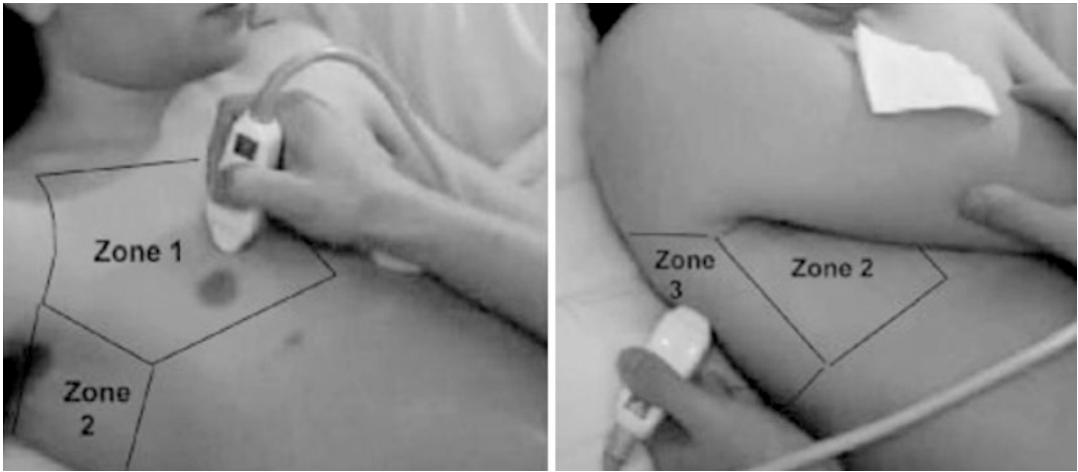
Exam zones for lung ultrasound
